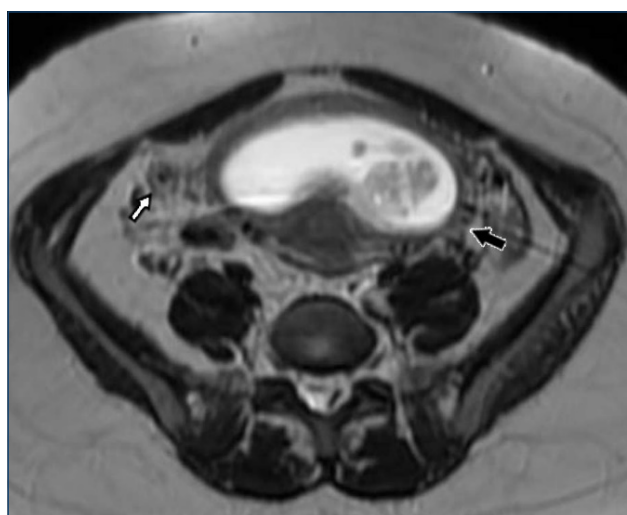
A 24-year-old pregnant patient in 16th week of gestation. Acute appendicitis (white arrow) with pericecal fat stranding and fetus (black arrow) are seen on axial T2-weighted sequence.
